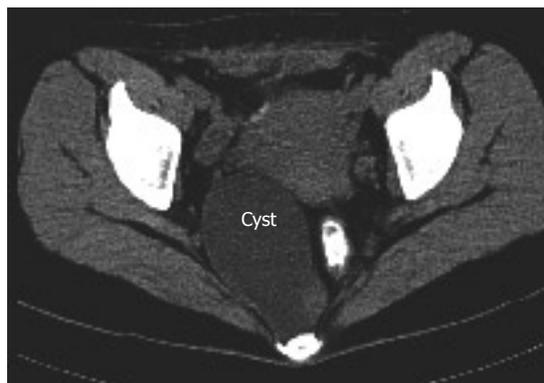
CT scan of cystic mass in the presacral space.
